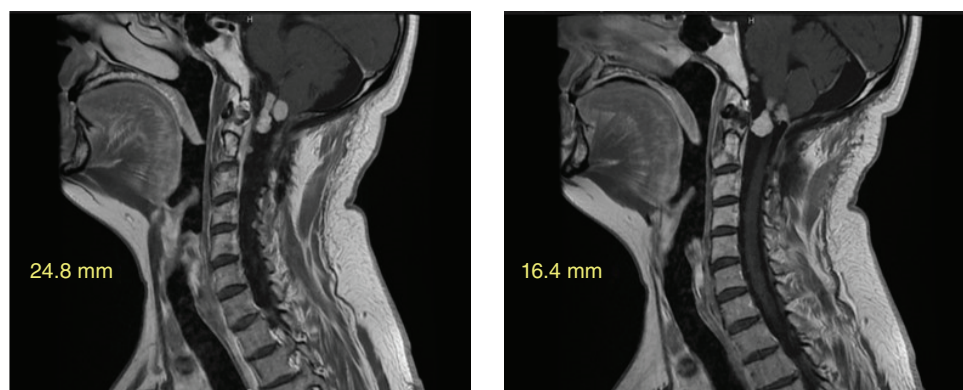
August 2020: adjacent slices from T1 MRI sequences showing response of cervical lesions to trabectedin (x 19 cycles).
